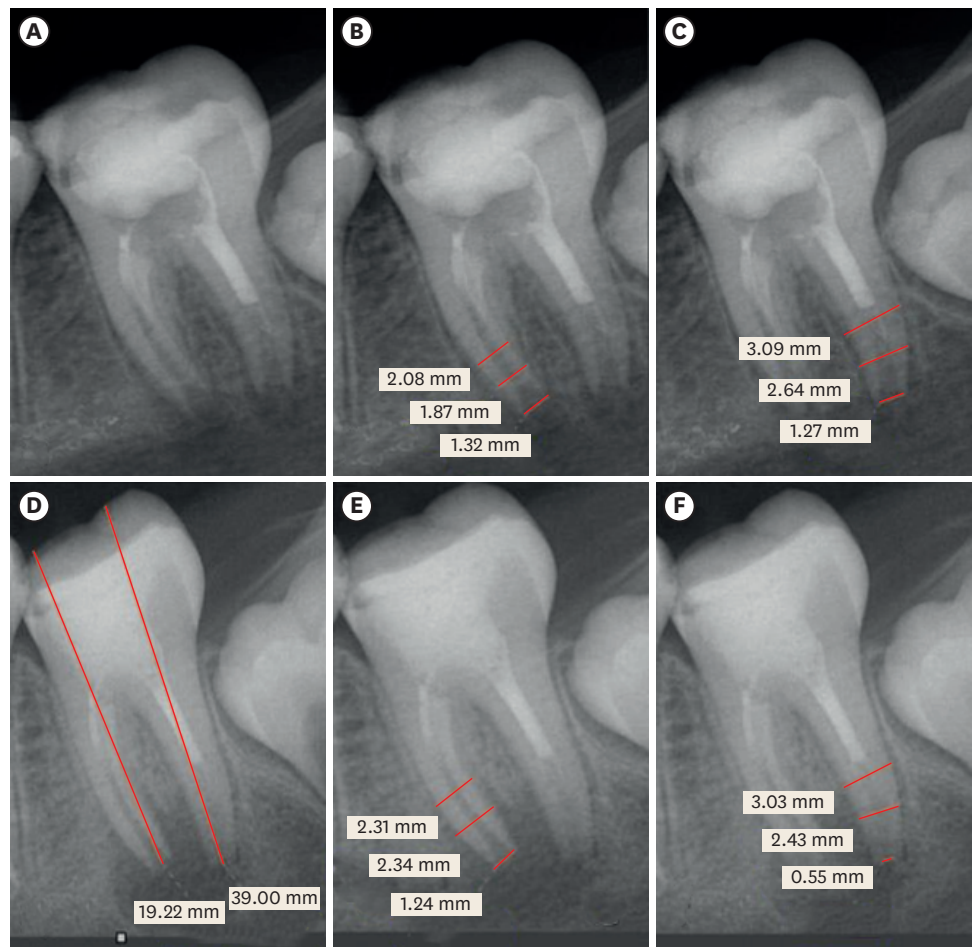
Mandibular left the second molar of 13-years old female patient with the open apex of both mesial and distal root and apical radiolucency due to caries. Calcium hydroxide was used as an intracanal medicament and the access and part of the canals were filled with mineral trioxide aggregate (A-C). 9 months post-operative radiograph shows complete apical closure of the distal root and reduction of the apical foramen width of the mesial root regardless of the increased apical radiolucency (D-F).
